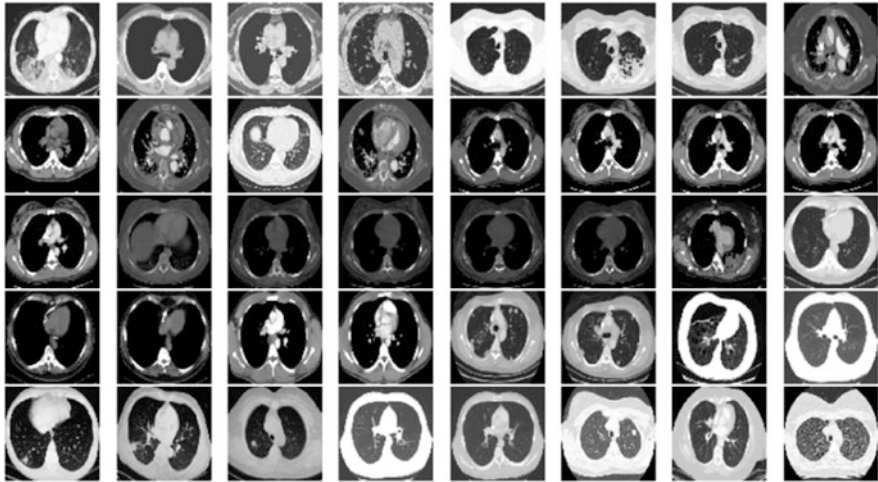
Negative Covid-19 using CT-scans
